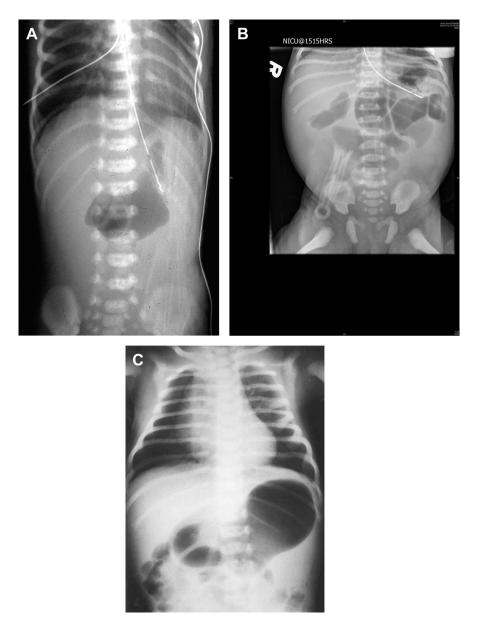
The varying appearances of malrotation on plain film. (*A*) Gasless abdomen with dilated gastric bubble; (*B*) dilated small bowel suggestive of a distal obstruction; (*C*) normal film with slightly dilated duodenum.
